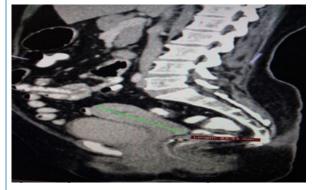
Axial CT scan showing the utero-cervical mass
